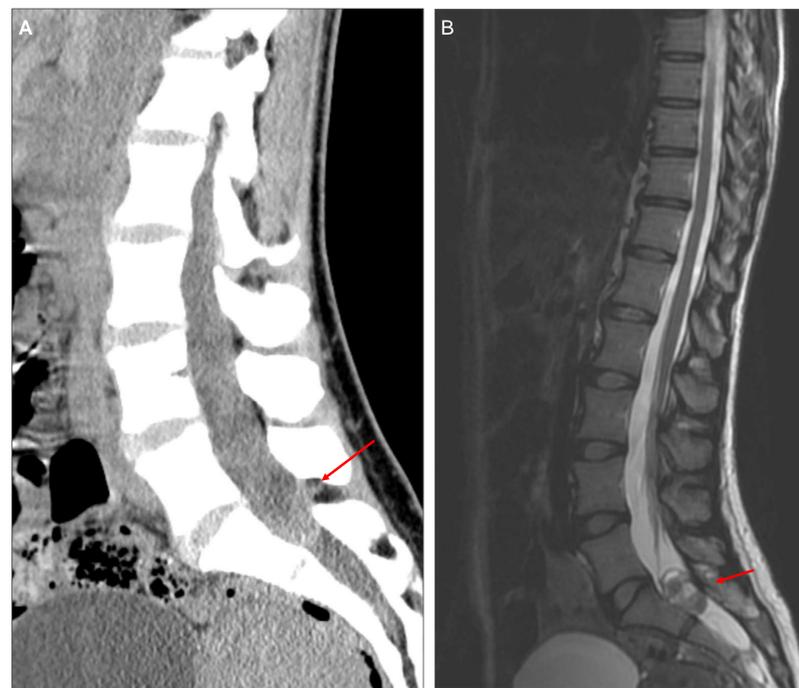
Lumbar Spine CT and MRI
